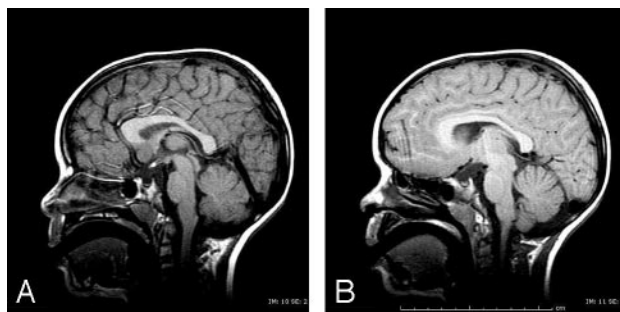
A, Sagittal T1-weighted image shows a hyperintensity corresponding to an ectopic posterior pituitary lobe located in the hypothalamic area. The pituitary is small. B, Paramedian sagittal T1-weighted image reveals a thin optic chiasm and a small pituitary.
